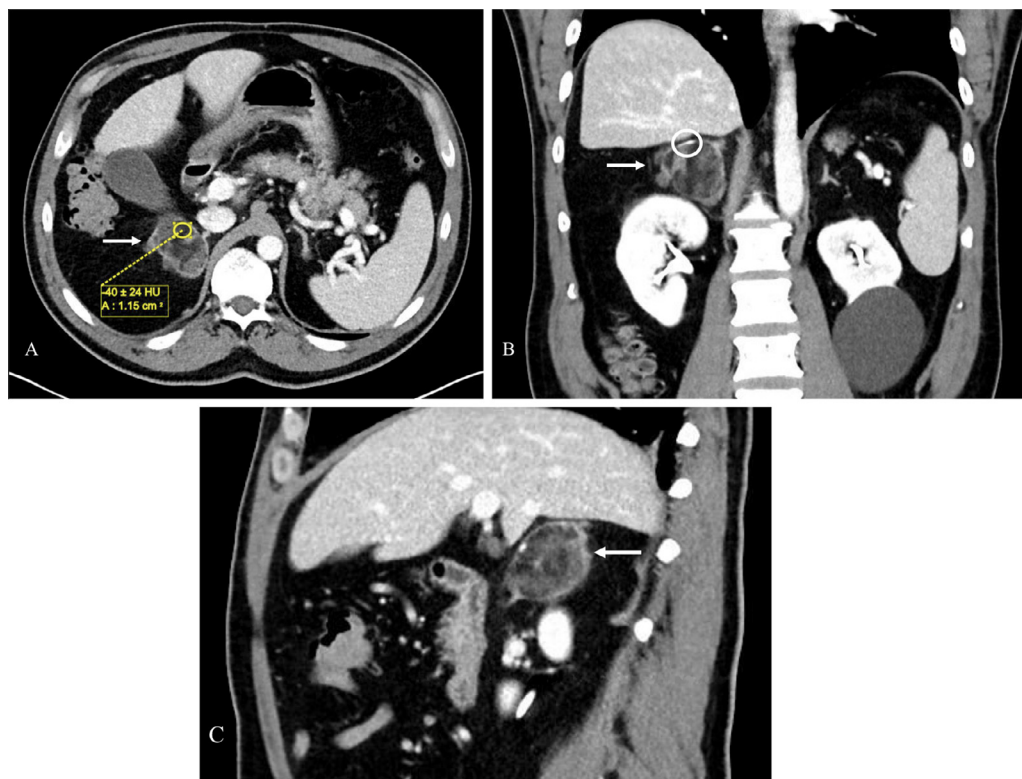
Fifty-three-year-old male with incidental right adrenal mass. Axial (a), coronal (b), and sagittal (c) images from contrast enhanced CT scan of the abdomen and pelvis demonstrate a 5.4 cm right adrenal mass (arrows) with a significant volume of macroscopic fat (as indicated by the region of interest on Fig. 1a with -40 ± 24 HU), calcifications (circle on Fig. 1b), and a lobulated contour and peritumoral fat stranding. There were intact fat planes between the right adrenal mass and surrounding structures.
